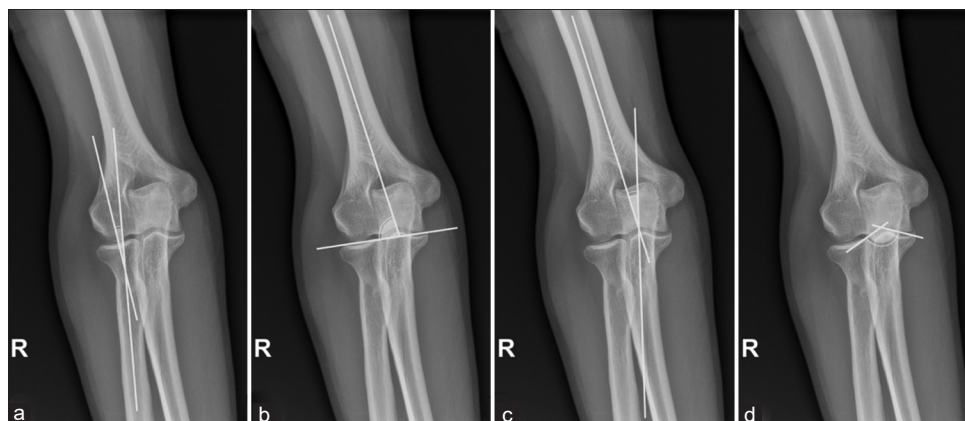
Standard elbow radiographic angles on the anteroposterior view. (a) Radial neck angle, (b) Articular surface angle, (c) Carrying angle, (d) Trochlear notch angle
